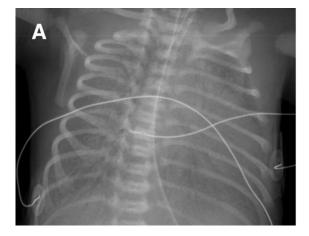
Chest roentgenograms of the neonate showing (A) severe, diffuse, bilateral alveolar infiltrates with air bronchograms, which (B) markedly improved within 12 hours of hydrocortisone administration.
